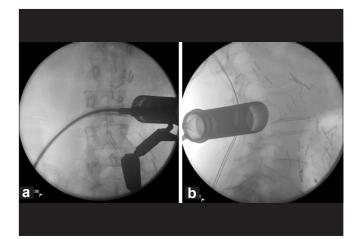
Intraoperative fluoroscopy: (a) AP and (b) lateral X-rays confirm adequate placement of the tubular retractor in between the L3 and L4 spinous process lateral to the L3-L4 facet complex
